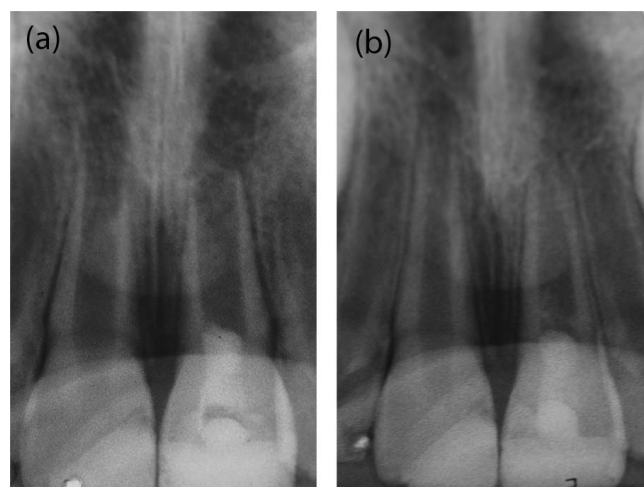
Radiographs after pulp revascularization (a) and after 18 months (b).
